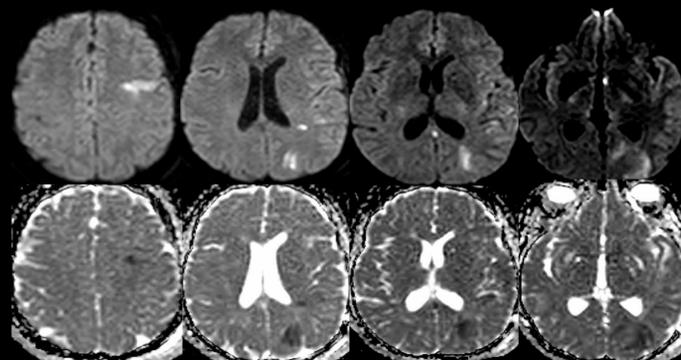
upper Row : DWI; Lower ROW : ADC
